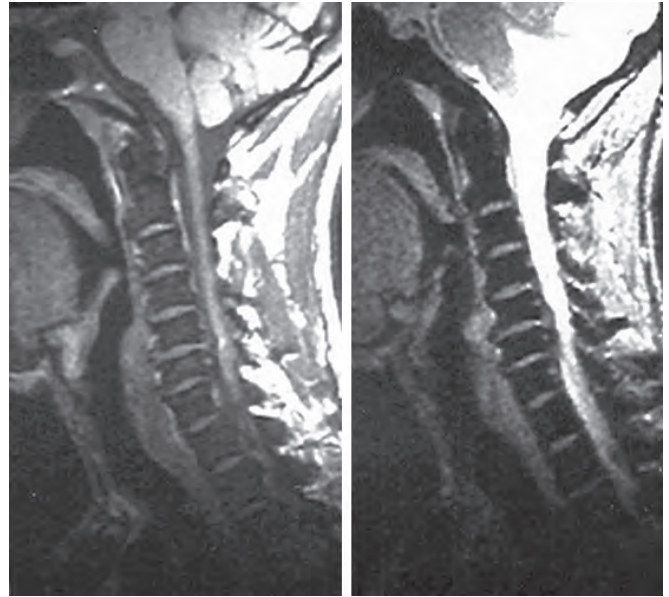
MRI scan of the cervical spine in fluorosis. Note pronounced low intensity of bone marrow both on T1- and T2-weighted images, calcification of posterior longitudinal ligament and myelomalacia opposite C5
